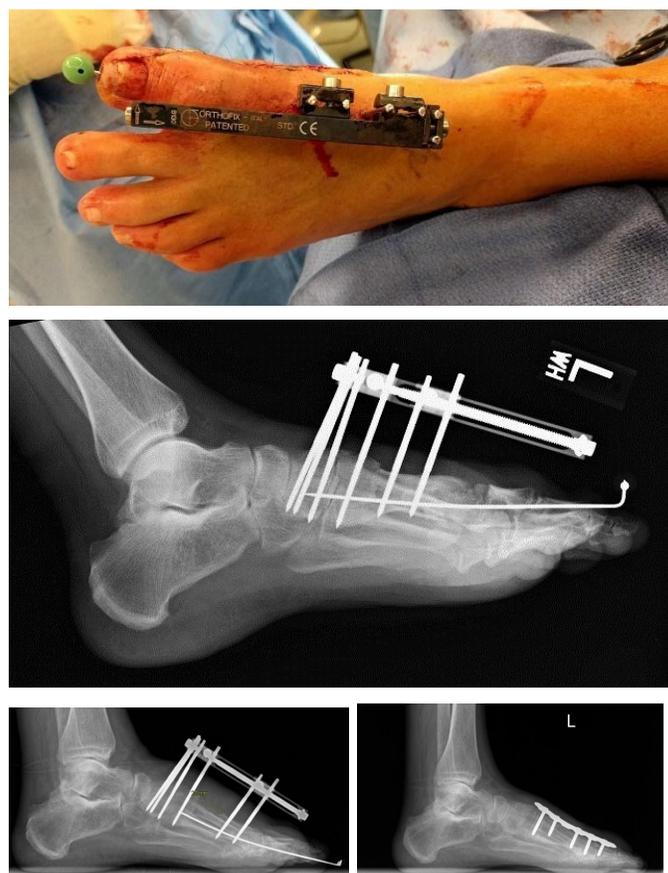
(A) Intraoperative, Closure with External fixator application (B) Immediate postoperative with compression at corticotomy site (C) X-ray after 26 days distraction, 22mm of lengthening (D) Consolidation period post external fixator removal and internal fixation.
